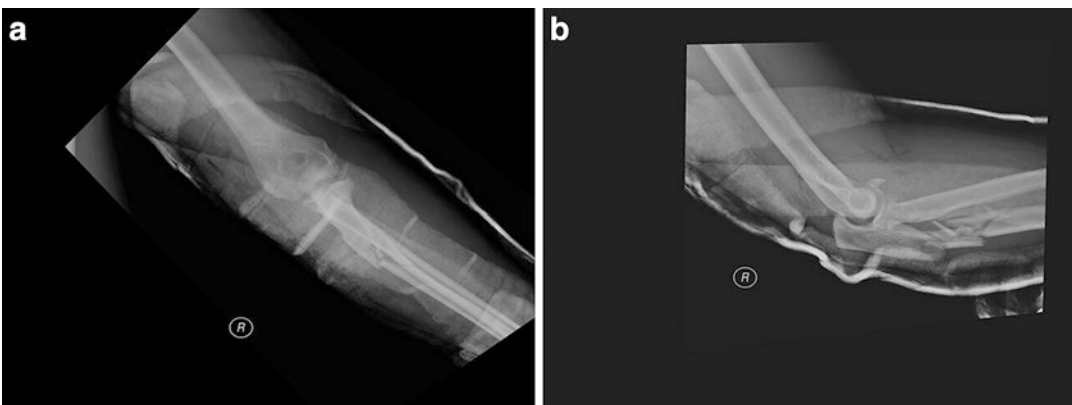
(a) Postreduction AP radiograph of the right elbow. (b) Postreduction lateral radiograph of the right elbow
